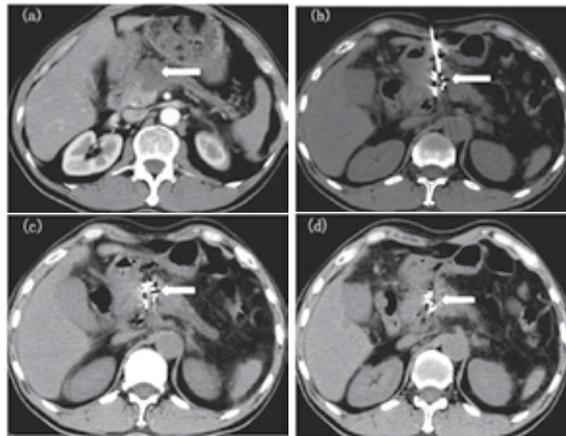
70-year-old male patient. Pancreatic carcinoma patient with ^{125}I seeds implant under CT guidance. (a) Preoperative contrast-enhanced CT scan shows a 3.0cm x 3.0cm tumor at the body of pancreatic carcinoma (arrow). (b) CT scan shows that ^{125}I seeds are implanted into the tumor via 18G implantation needles (arrow). (c) CT scan shows the distribution of ^{125}I seeds post implantation (arrow). (d) 2 months follow-up. CT scan shows pancreatic tumor partially decreased and ^{125}I seeds gathered together (arrow).
